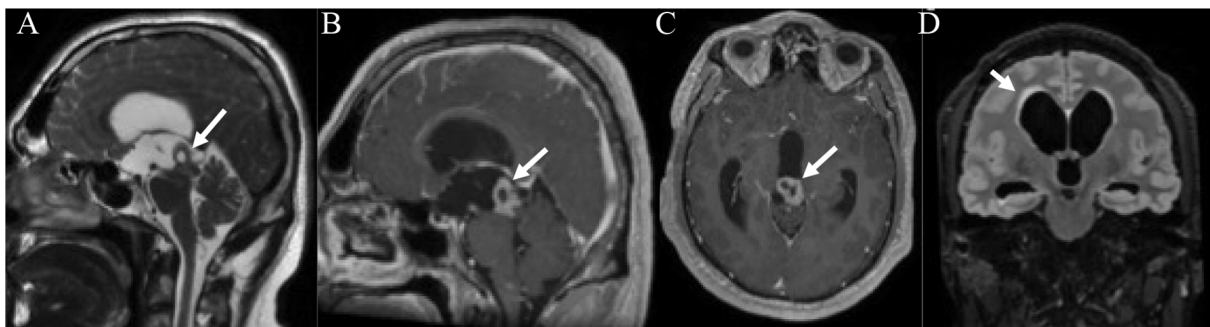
Preoperative MRI: sagittal T2-weighted (A), sagittal (B) and axial (C) and post-gadolinium T1-weighted images showing a strongly enhancing pineal mass composed of solid (white arrow) and cystic components. Coronal (D) FLAIR weighted-image demonstrating an obstructive hydrocephalus with transependymal edema (white arrow).
